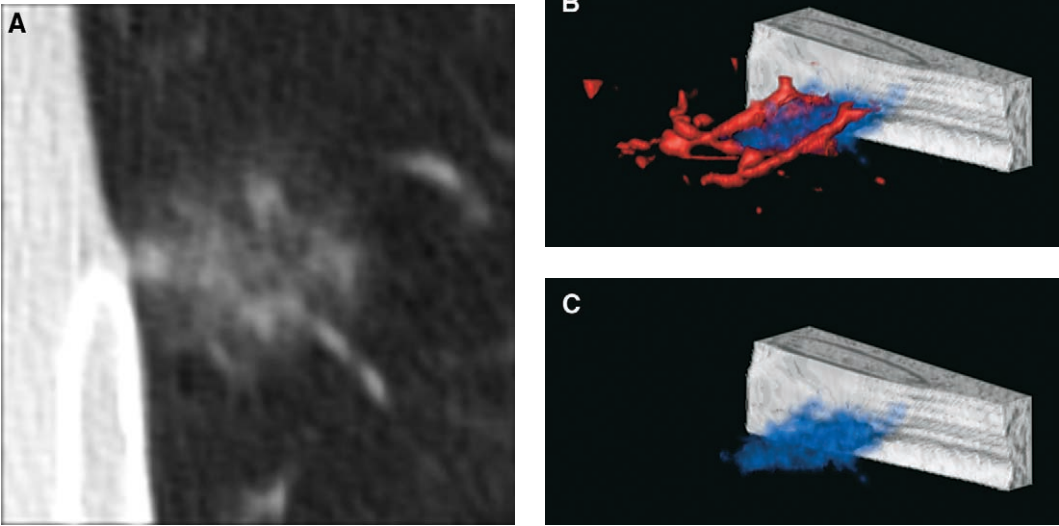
Visualization of a nonsolid nodule. (A) CT image. (B) Rendered as a translucent blue region with vessels marked in red. (C) With vessels removed.
